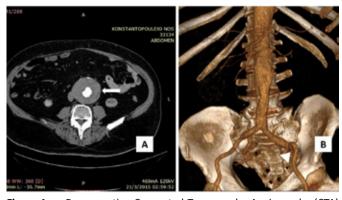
a. Pre-operative Computed Tomography Angiography (CTA) revealed the 7.5 cm infra-renal abdominal aortic aneurysm with extended mural thrombus (arrow). b. 3-D reconstruction of the pre-operative CTA showing the small patent lumen with the angulated left common iliac artery and the tortuous left external iliac artery (arrowhead).
